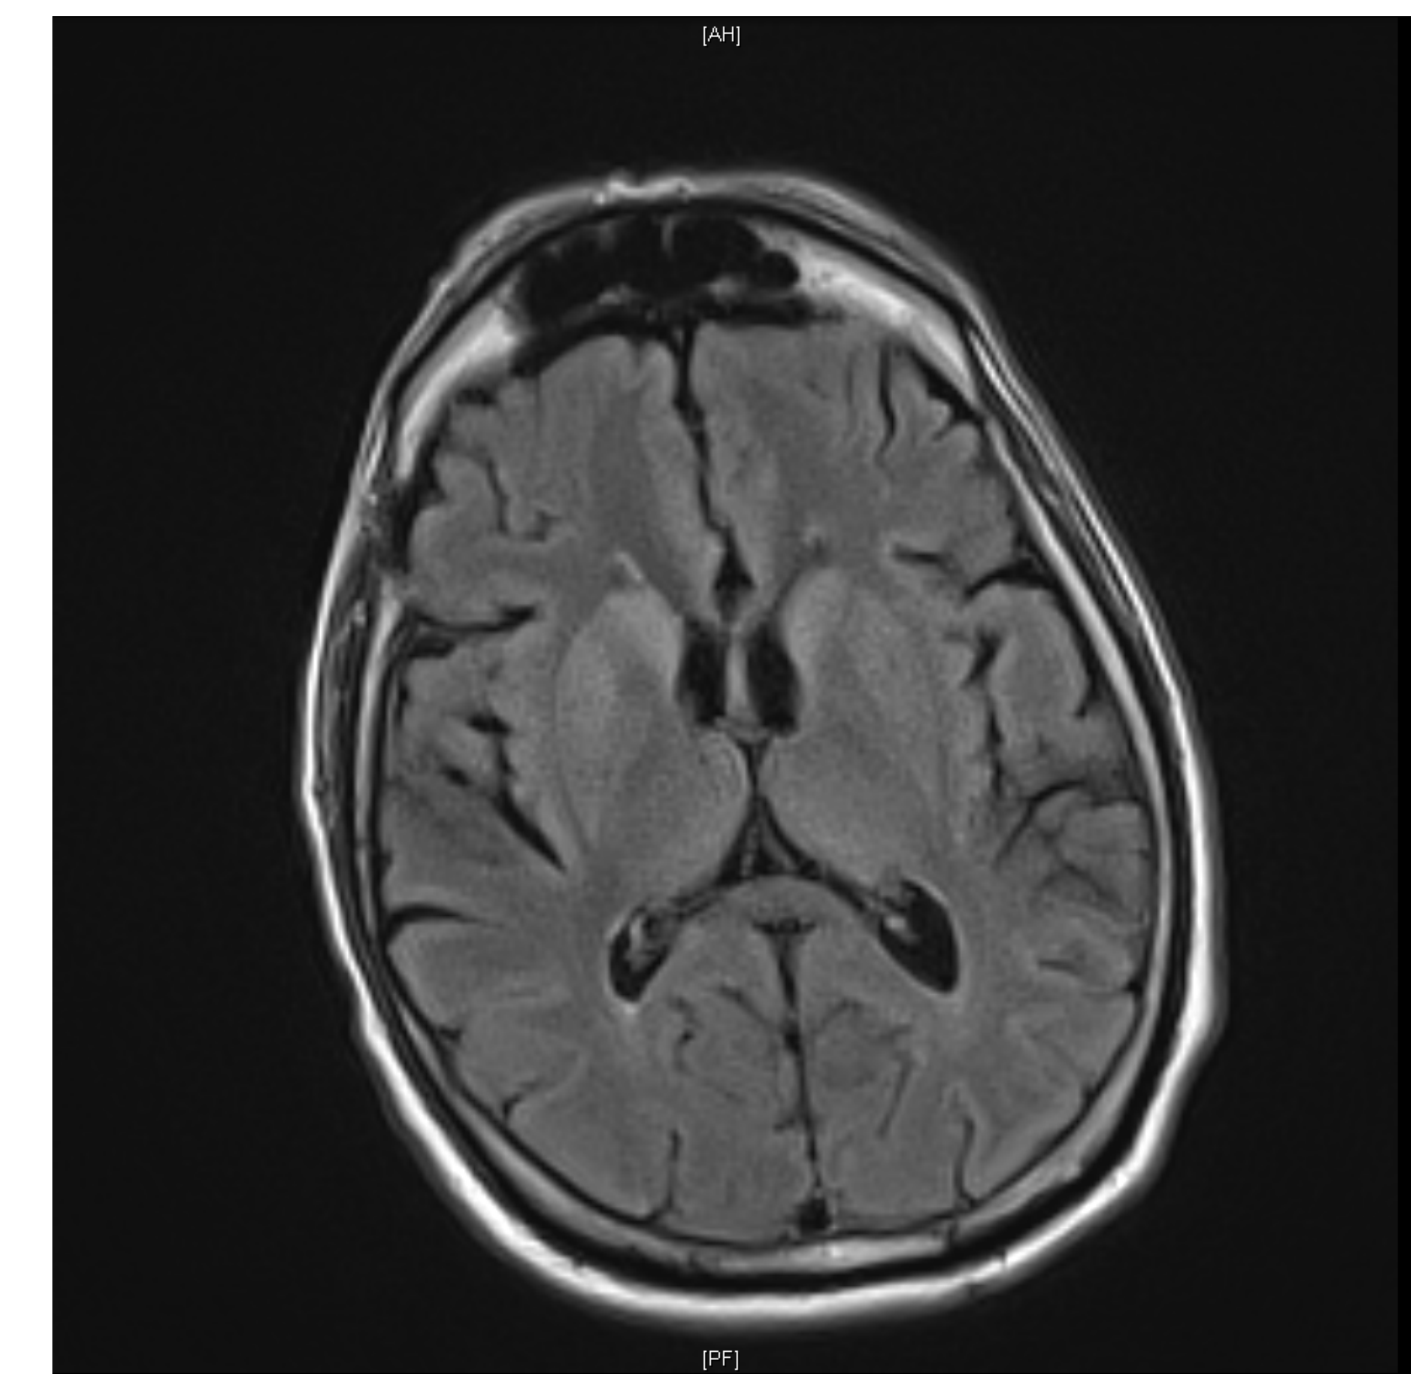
MRI Brain T2-weighted fluid-attenuated inversion recovery (FLAIR) image showing increased diffusion restriction with hyperintense signal involving the bilateral caudate nuclei and lentiform nuclei (mostly putamen). Not pictured: similar changes in the bilateral hippocampi. These findings are not typical of neurofascin neuropathic process but consistent with prion disease.
